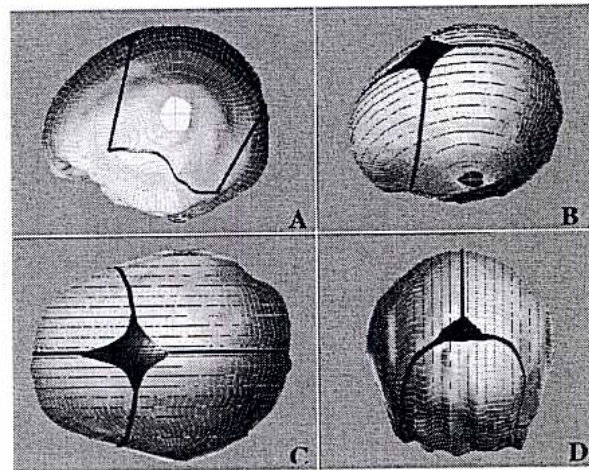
(A) Side, (B) 3D, (C) top, and (D) rear views of the skull and suture geometry derived from MRI and CT images of a 5 week old male infant.
